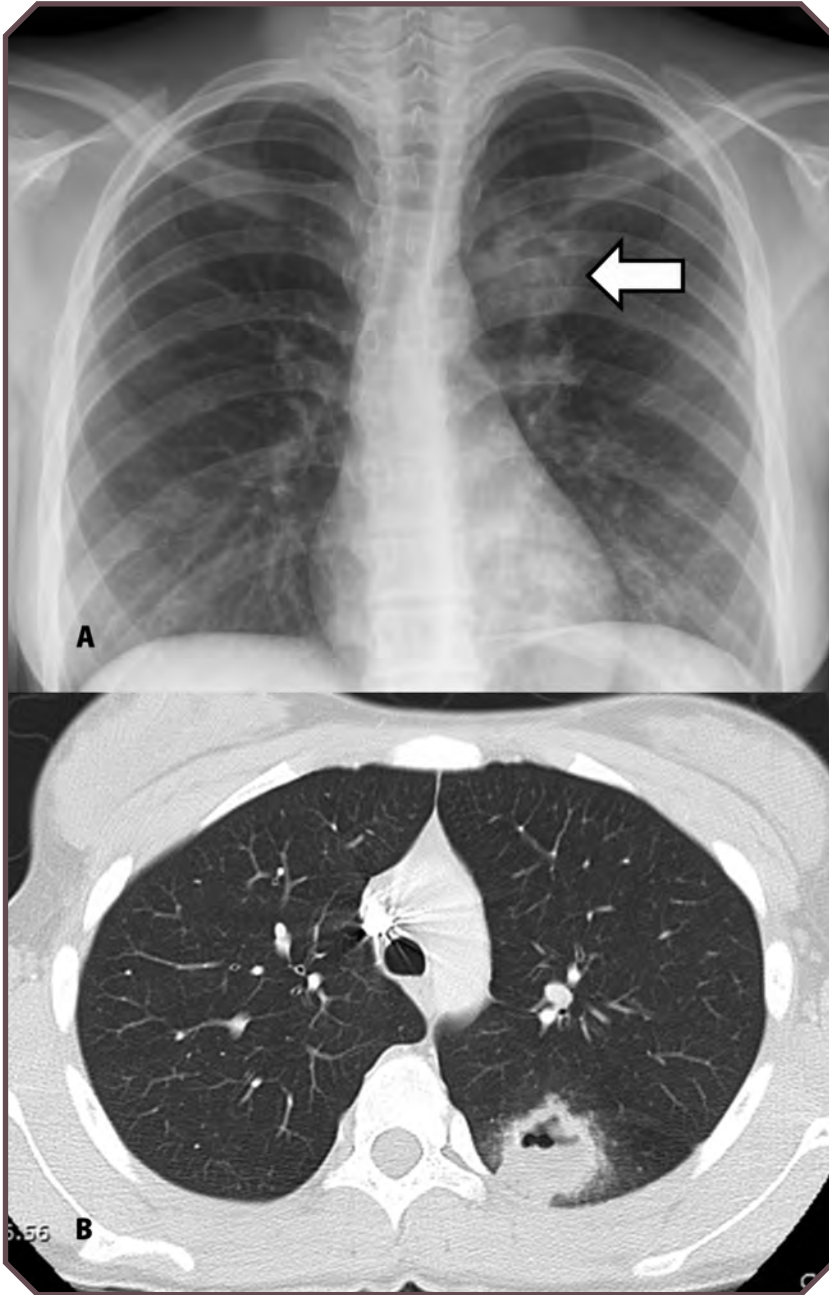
Complicated pneumonia with left upper lobe abscess in a teenaged girl. A. Frontal chest radiograph demonstrates a left upper lobe focal opacity with central air (arrow). B. Axial chest computed tomographic image confirms an air-containing opacity in the left upper lobe, with a thick wall and irregular margins, which are typical of focal abscess.
